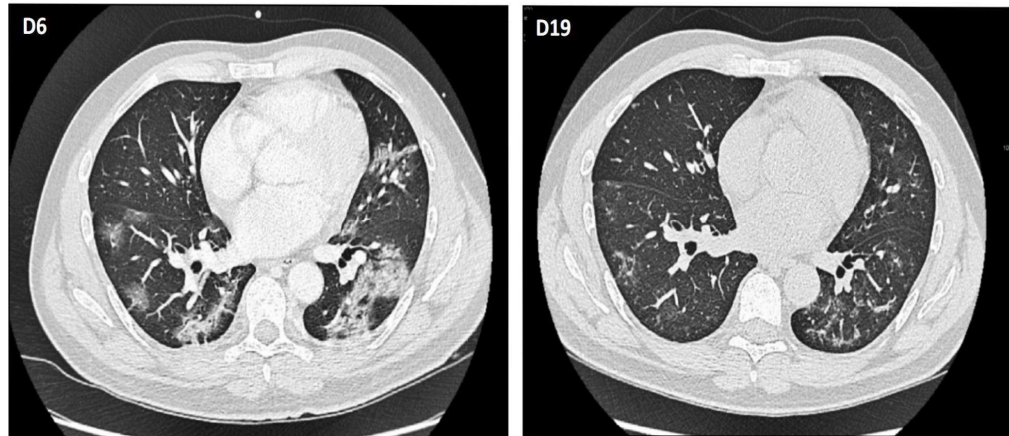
Pulmonary CT scan (Computerized tomography) of the patient before (day 6) and after (day 12) of tocilizumab administration shows Gradual recovery.
